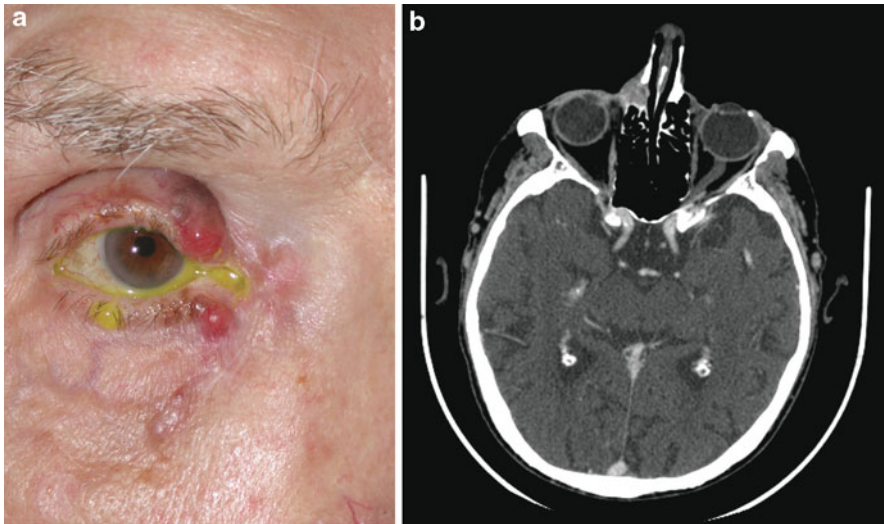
(a) Melanoma metastatic to the lacrimal sac and periorbital soft tissue in a 90-year-old man with stage IV cutaneous melanoma. (b) Computed tomography scan in the same patient demonstrating the metastatic melanoma lesion in the lacrimal sac
